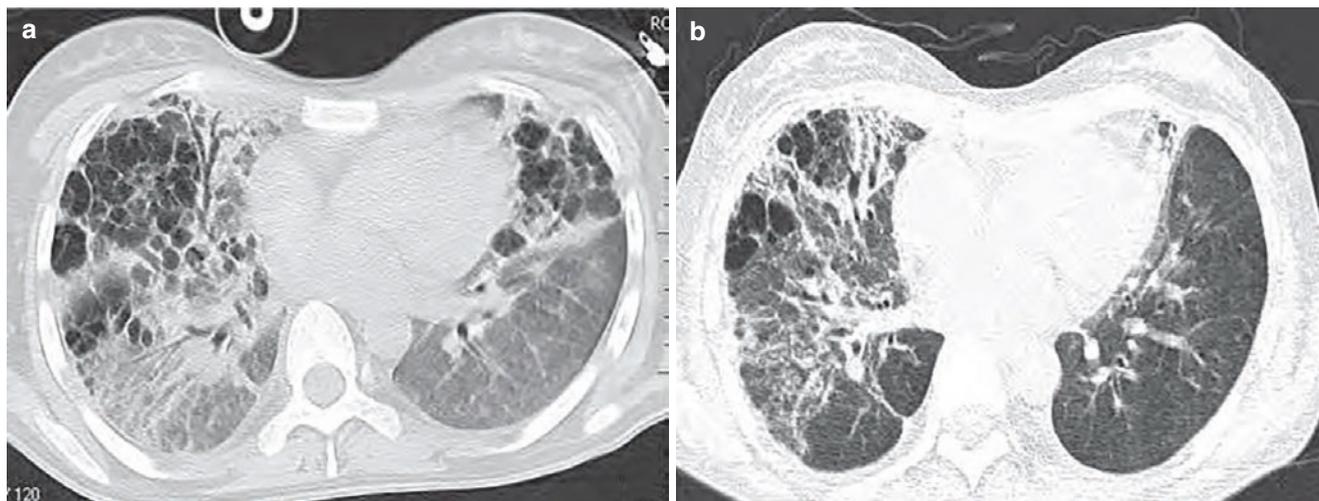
Acute interstitial pneumonia (II). (a) CT lung window showed multiple patchy opacities, ground-glass opacities, cystic opacities in both lungs, and local bronchus showed mild bronchiectasis due
